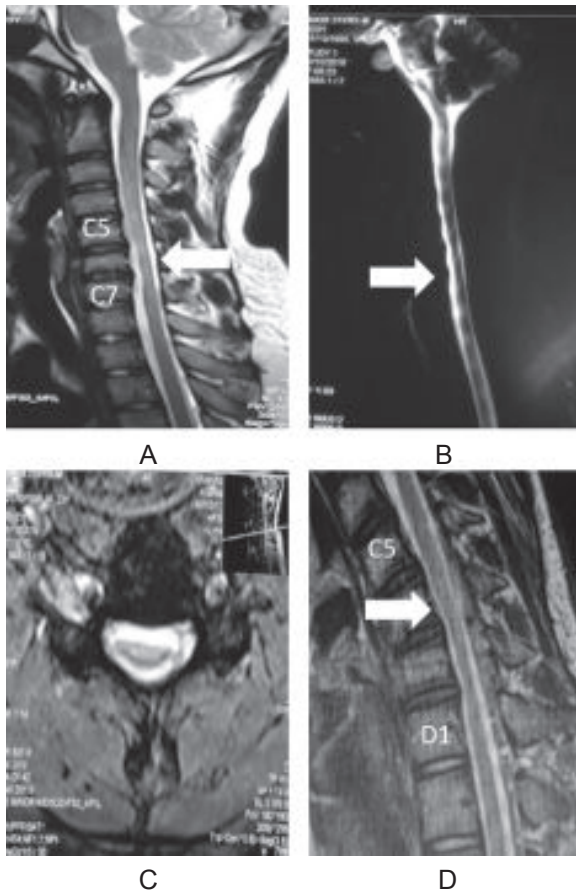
MRI of cervical spine. T2 sagittal (A & B) section showing focal cord atrophy (C5-C7 vertebral level), T2 axial © section showing marked anterior-posterior flattening of cord, T2 sagittal in flexed position (D) showing posterior dural sac shifting anteriorly with flattened cord compression against posterior surface of C5 to D1 vertebral bodies.
